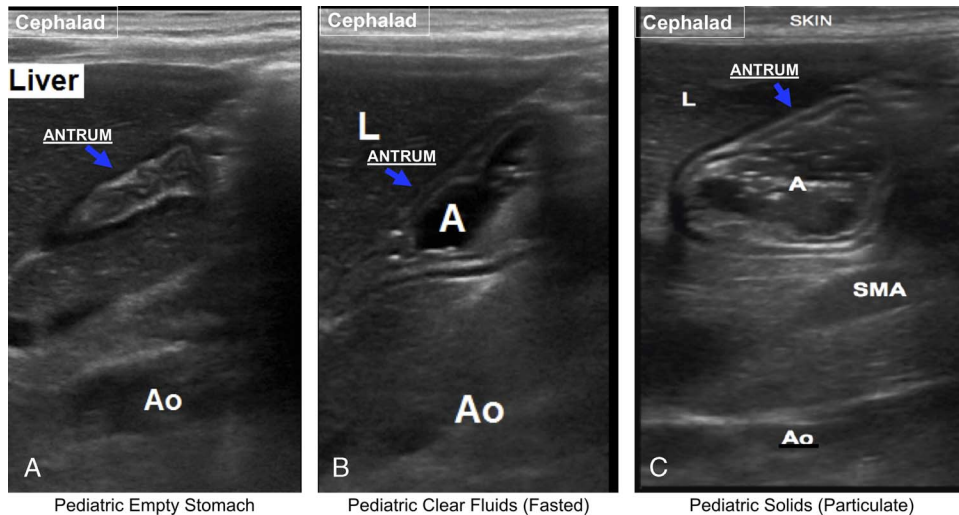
Sonographic image of the gastric antrum in a 5-year-old child imaged with a high-frequency linear probe in the RLD position. A, Empty antrum. B, Clear fluid (fasting). C, Solid (particulate). A indicates antrum; Ao, aorta; L, liver. Images are courtesy of Dr Adam Spencer from Calgary Children's Hospital.
